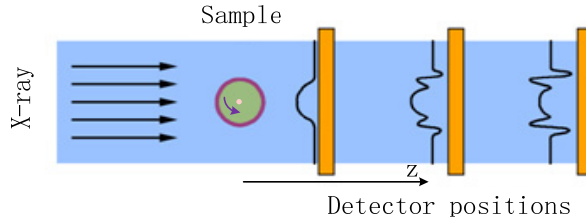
The scanning configuration for PBI PC-CT.
